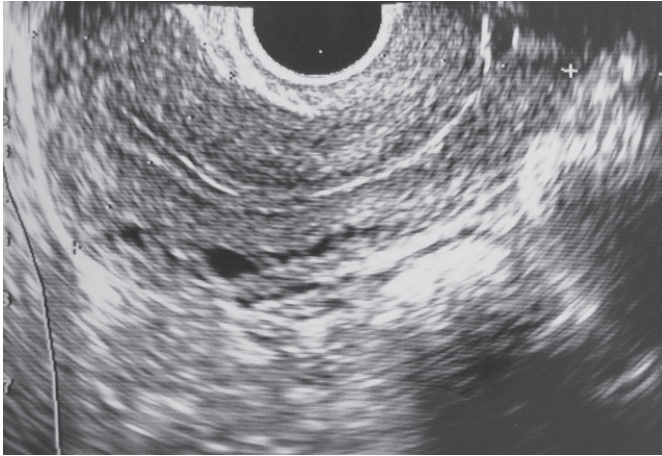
Ultrasonography Demonstrating Normal Endometrial Stripe (<5 mm)
